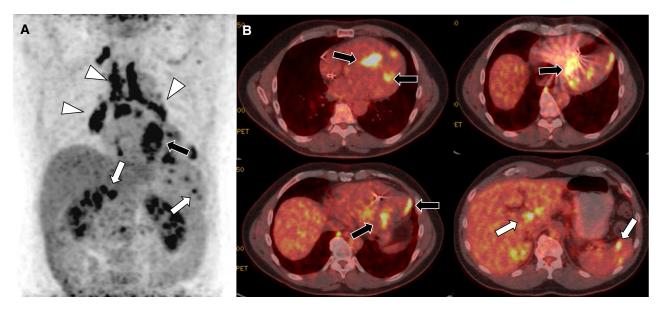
Coronal MIP (A) and a set of fused axial chest and upper abdominal images (B) from FDG PET-CT after 72-hour HFHPVLC diet preparation. This patient demonstrates typical mediastinal and bilateral hilar lymphadenopathy of sarcoid (*white arrow heads*). There are also multiple foci of myocardial radiotracer uptake consistent with CS (*black arrows*). Inspection of the upper abdomen reveals sarcoidosis in the spleen and porta hepatic lymph nodes (*white arrows*).
